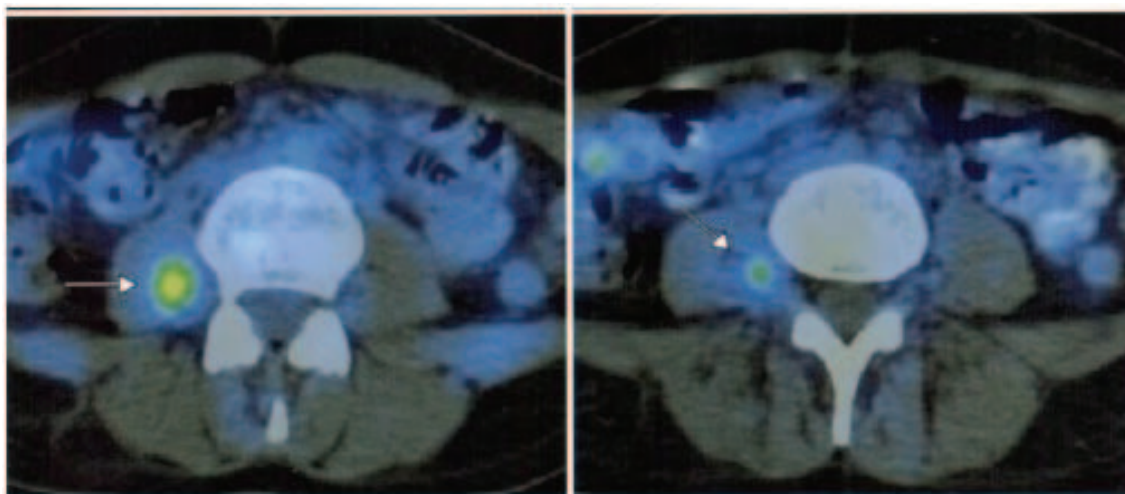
Positron emission tomography-computed tomography (PET-CT) scan: an enlarged lymph node, suspicious of metastases, is visible between the right psoas muscle and the spinal column.
